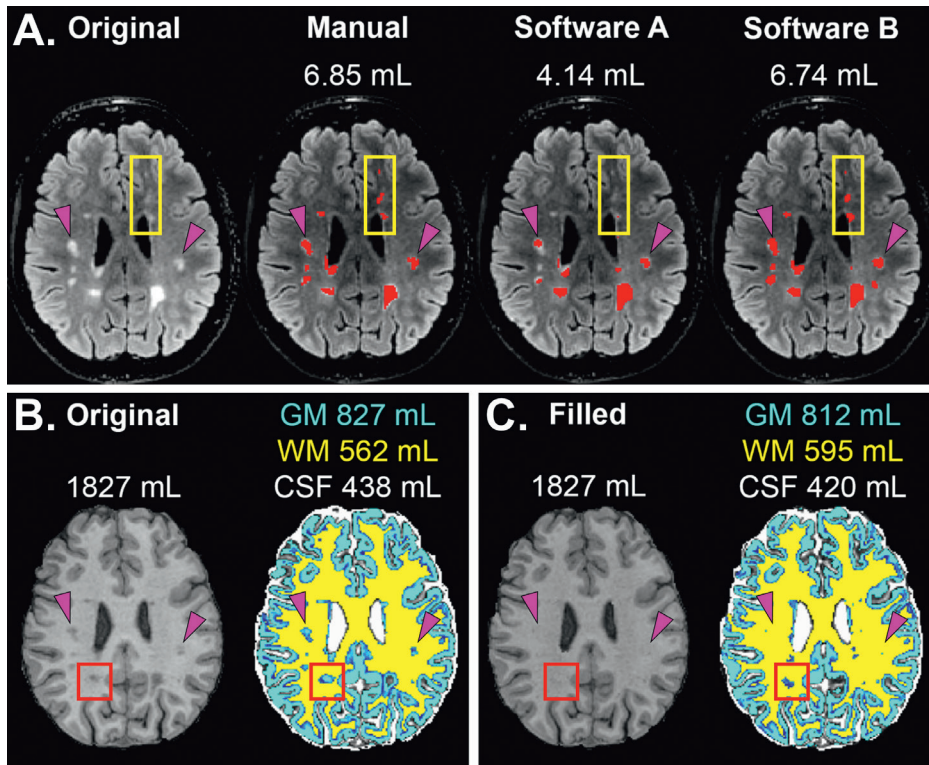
Example of challenges that occur in the presence of MS lesions in brain MRI. Pink arrows correspond to the same locations in the T2-FLAIR (top row) and T1 (bottom row) images. The original T2-FLAIR image and three different lesion segmentation methods (manual and two different software packages) with their measured lesion volumes are shown in A. The yellow box highlights differences between the methods. Segmentation of the original T1 image with lesions present (B) yields different GM and WM volumes compared to the T1 image in which lesions are filled with the signal intensity of normal-appearing WM (C). The red box highlights that even with lesion filling, lesions may still be recognized as GM when they are not optimally segmented.
